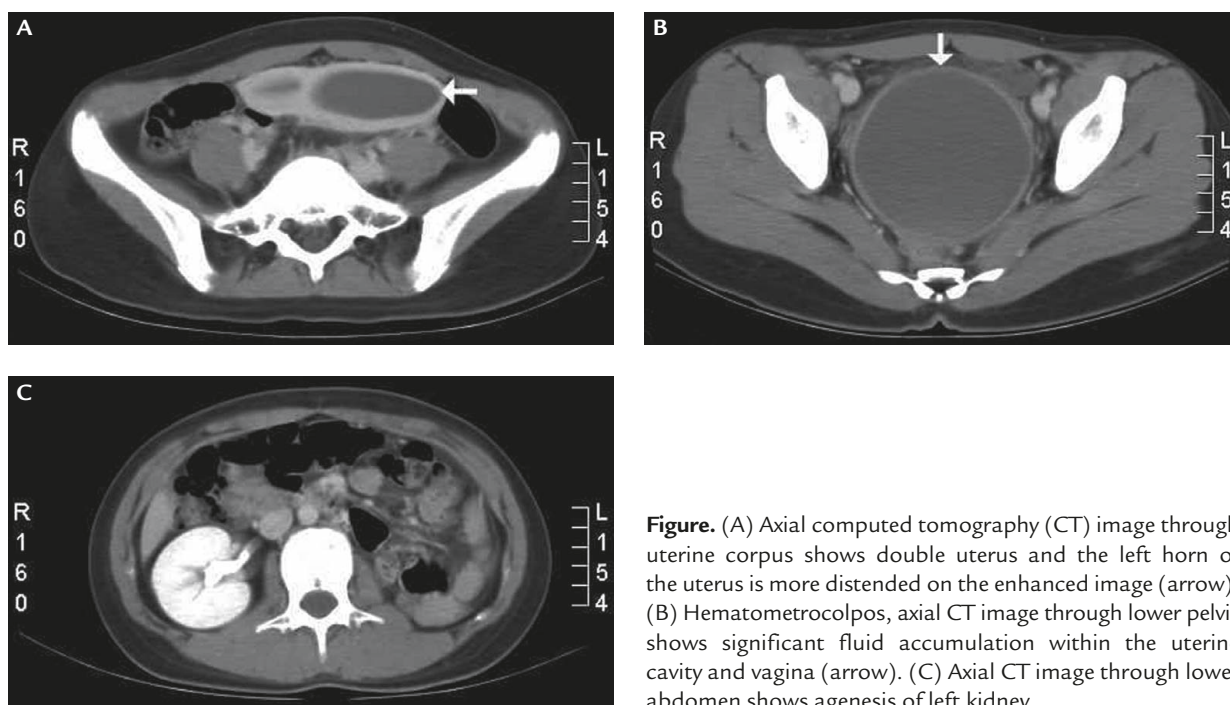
(A) Axial computed tomography (CT) image through uterine corpus shows double uterus and the left horn of the uterus is more distended on the enhanced image (arrow). (B) Hematometrocolpos, axial CT image through lower pelvis shows significant fluid accumulation within the uterine cavity and vagina (arrow). (C) Axial CT image through lower abdomen shows agenesis of left kidney.
